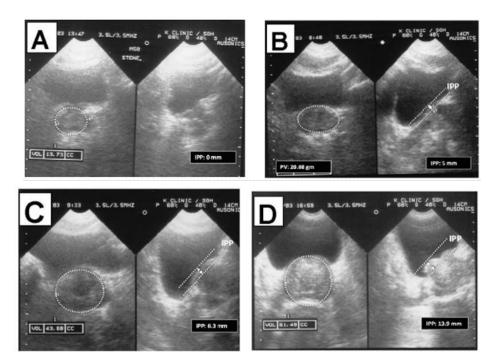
Ultrasound image, A) Normal prostate, no protrusion. B) Grade 1, protrusion 5 mm or less. C) Grade 2, protrusion of more than 5 to 10 mm Grade 3, protrusion more than 10 mm (Wang et al., 2015).
